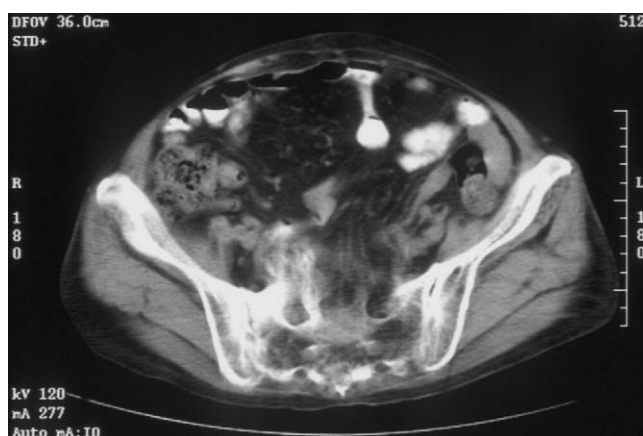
Computed tomography of the second case.
